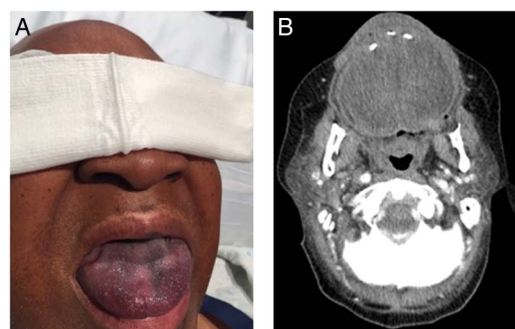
(A) Marked swelling of lips and tongue. (B) CT scan of the head and neck showed narrowing of upper airways.
